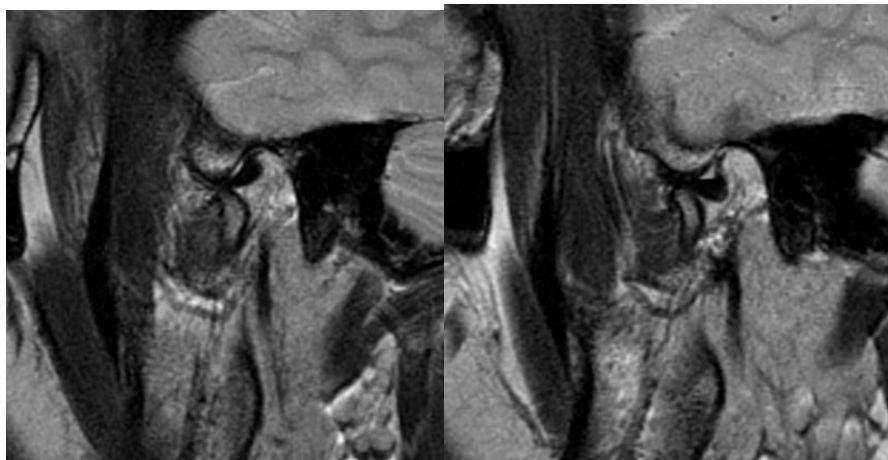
Post-Treatment Sagittal T2 Weighted MRI in open mouth position of right (a) and left (b) TMJ show normal 'bow-tie' appearance suggesting disc recapture
